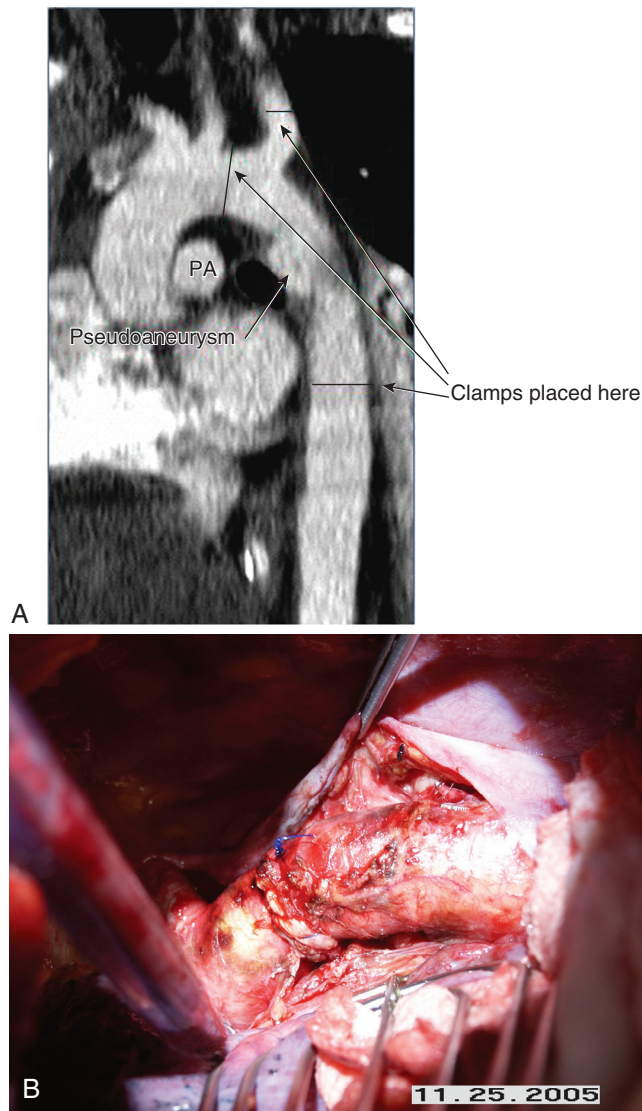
■ A, Blunt aortic injury with a pseudoaneurysm seen on computed tomography scan. B, The injury was repaired primarily using a clamp and sew technique through a left thoracotomy. *PA*, Pulmonary artery.
